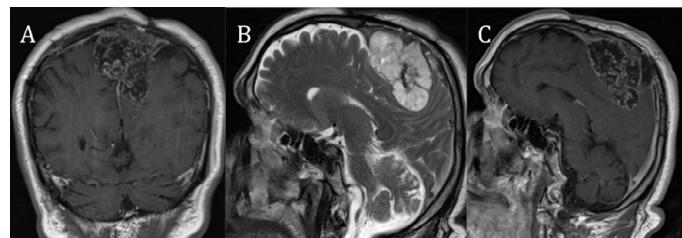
Preoperative T1-weighted (A), T2-weighted (B) and postcontrast T1-weighted axial MRI study revealed resection of the tumor. MRI showed a large parasagittal region with tumor calcification.
